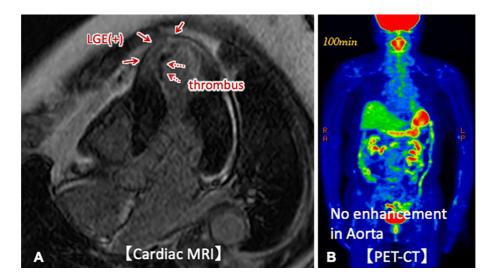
(A) Cardiac magnetic resonance imaging (MRI) revealed transmural late gadolinium enhancement at the apex of the antero-septal wall and thrombus in the left ventricular apex. (B) There was no enhancement in the aorta on PET-CT. MRI: magnetic resonance imaging, LGE: late gadolinium enhancement, PET-CT: positron emission tomography computed tomography
